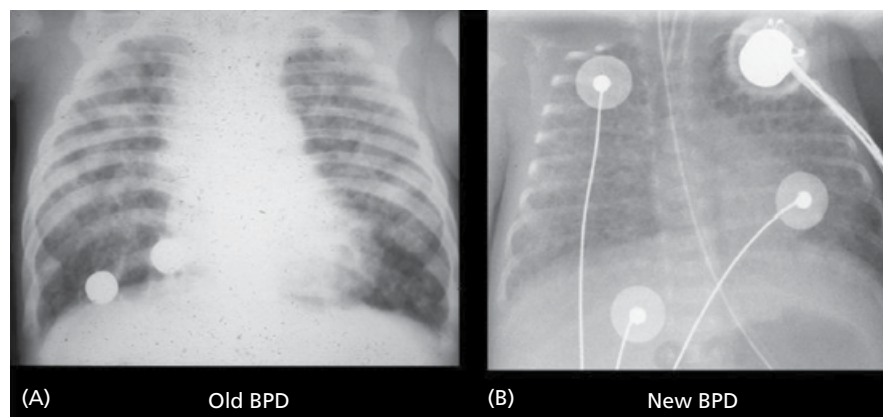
Radiographic picture of bronchopulmonary dysplasia (BPD). (A) Old BPD: areas of atelectasis and hyperinflation. (B) New BPD: diffuse opacification of lung fields. *Source:* Reproduced from Gupta et al [73] with permission of Elsevier.
